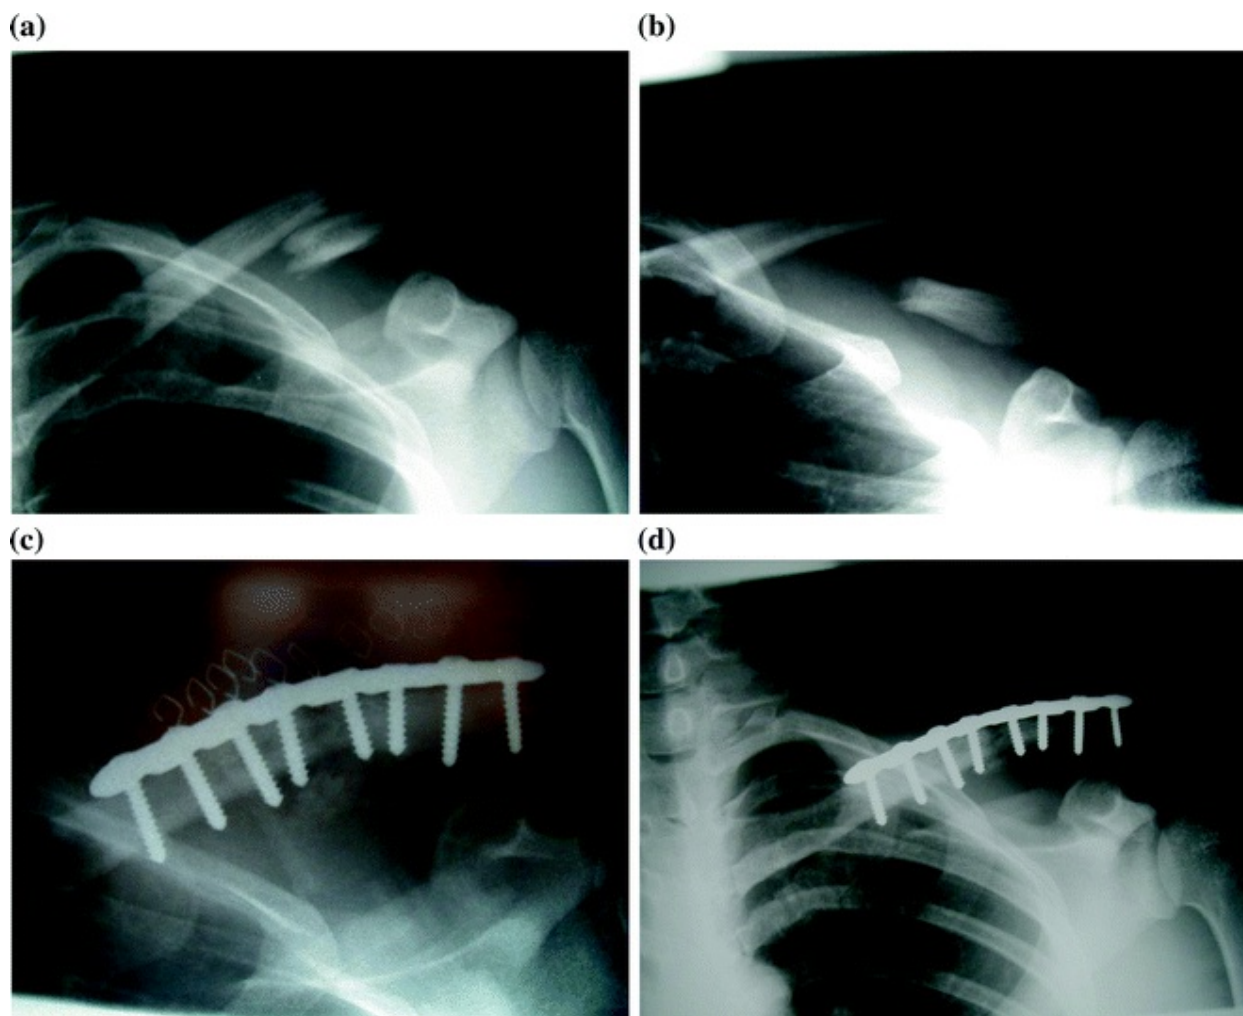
a Preoperative radiograph of a midshaft clavicle fracture in a 25-year-old female. b The patient was treated nonoperatively and went on to develop a symptomatic atrophic nonunion with severe displacement. c Post-operative radiograph of midshaft clavicle nonunion following open reduction and internal fixation with a precontoured plate and an iliac crest bone graft. d Radiograph of healed midshaft clavicle fracture at final follow-up
